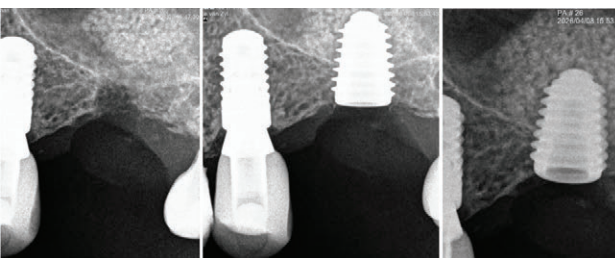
On the left the osteotomy site can be seen and the bone is introduced into the sinus through this using the bone carrier (shown in video). Radiographs show the egg shaped graft indicating a successful lift of the sinus Schneiderian membrane.
